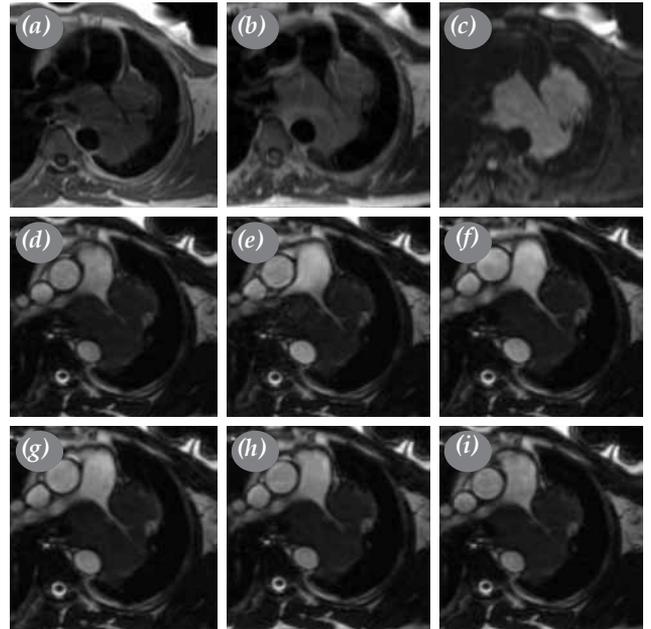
(a) T₁ hypointense; (b) T₂ hypointense; and (c) central lung mass that was hyperintense on short time inversion recovery (d-i) along with right pulmonary artery decompression and left pulmonary artery dilatation on cine magnetic resonance imaging.
